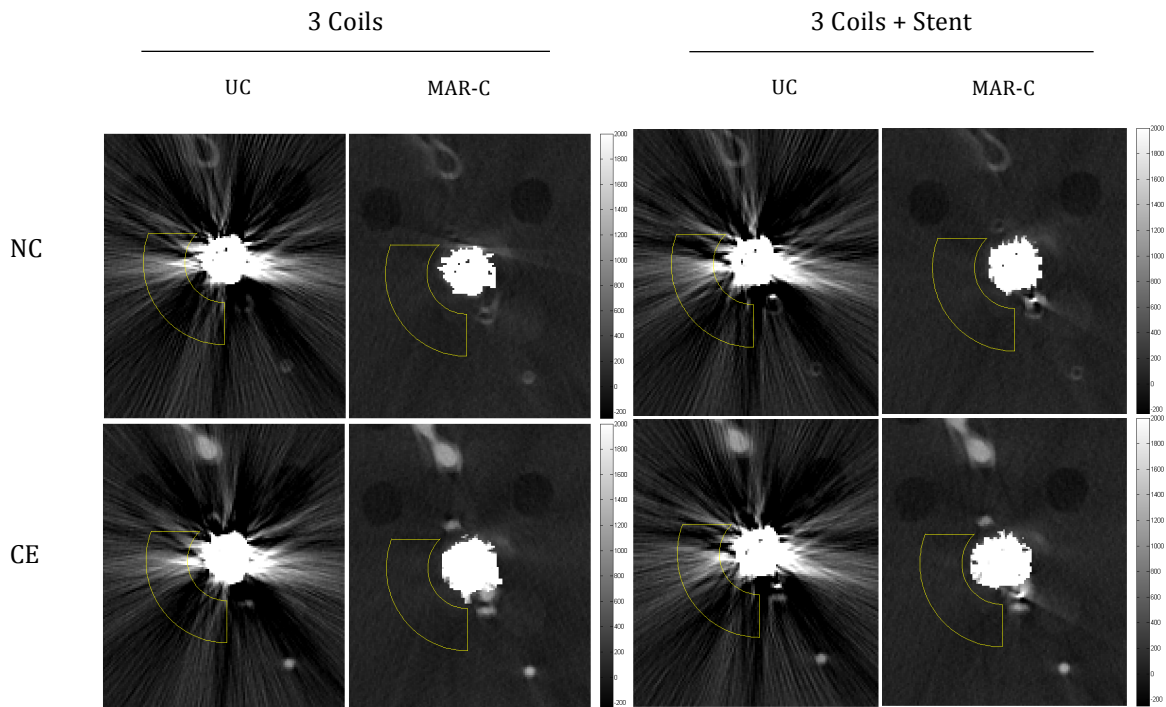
Uncorrected (UC) and MAR corrected (MAR-C) CT images of 3 coils with and without a stent, both with non-enhanced (NC) and contrast-enhanced (CE) solutions. Background ROIs are shown in yellow.
